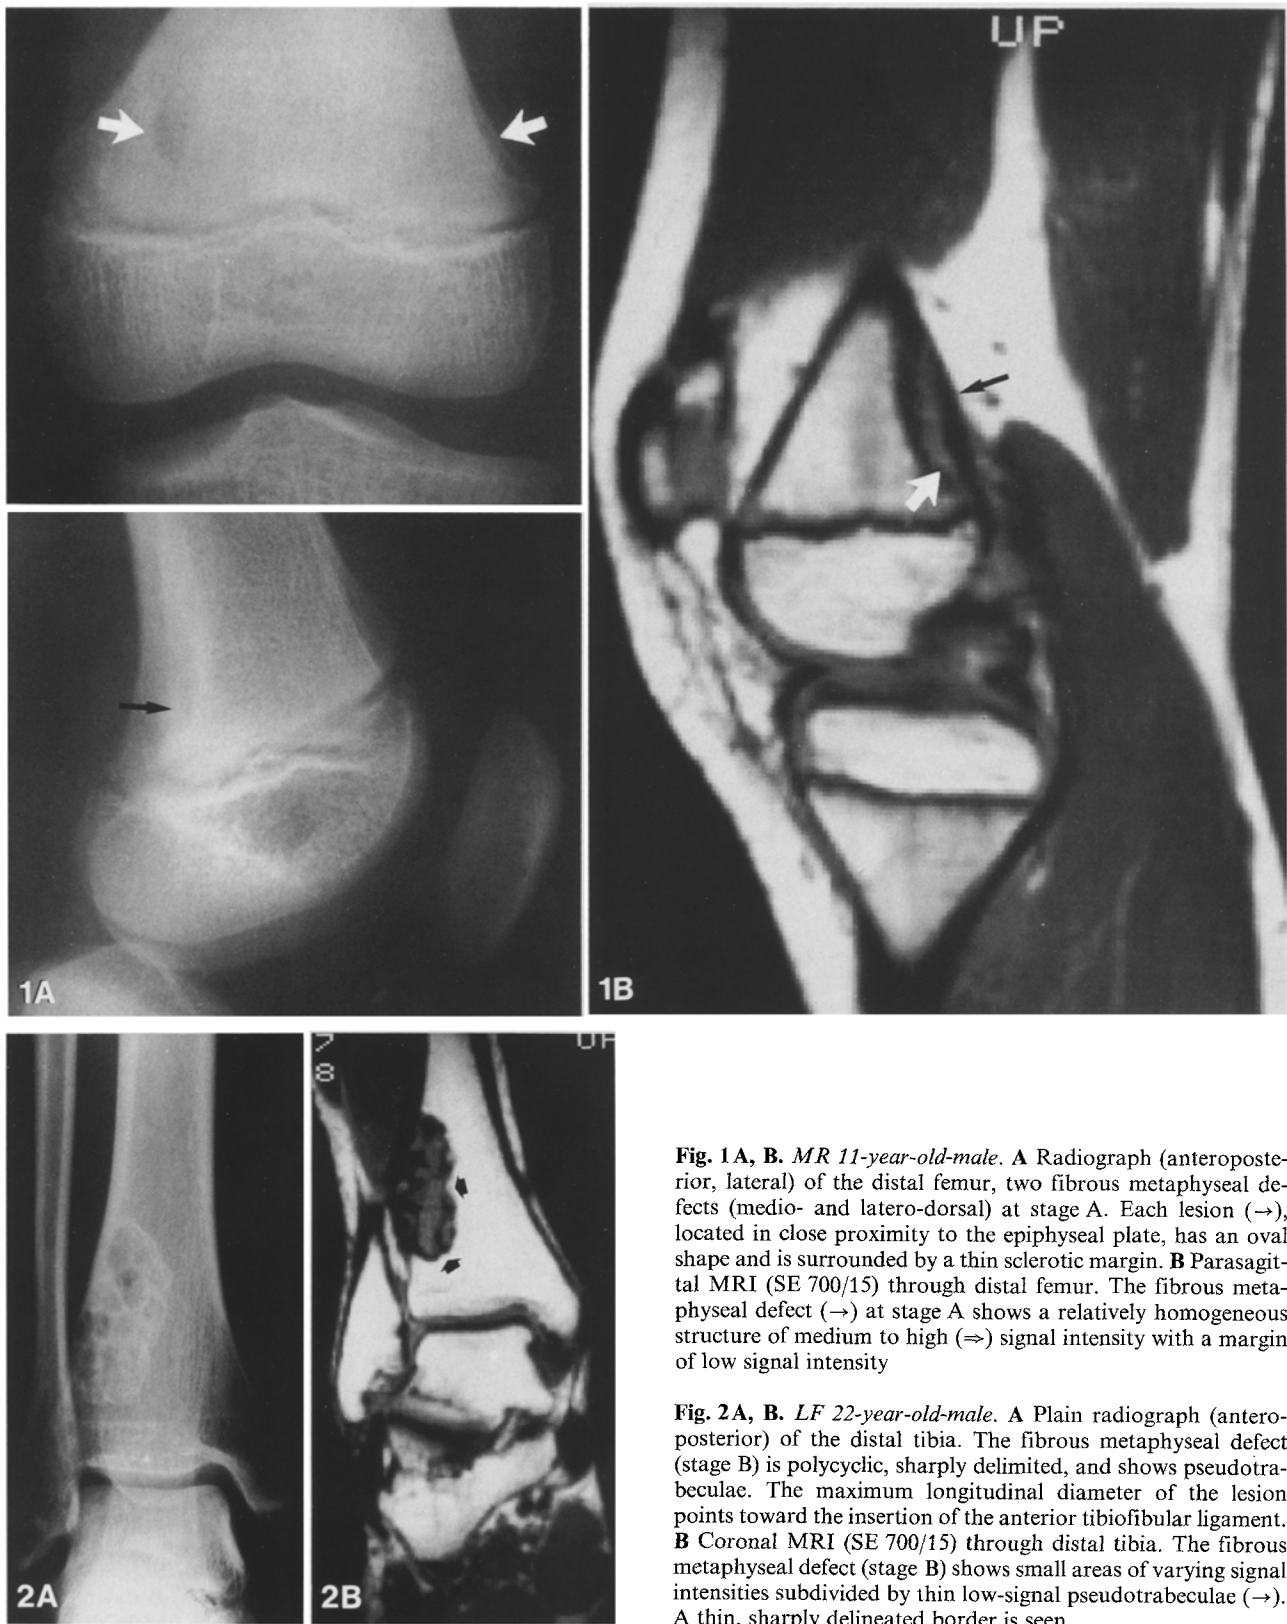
MR 11-year-old-male. A Radiograph (anteroposterior, lateral) of the distal femur, two fibrous metaphyseal defects (medio- and latero-dorsal) at stage A. Each lesion (→), located in close proximity to the epiphyseal plate, has an oval shape and is surrounded by a thin sclerotic margin. B Parasagittal MRI (SE 700/15) through distal femur. The fibrous metaphyseal defect (→) at stage A shows a relatively homogeneous structure of medium to high (⇒) signal intensity with a margin of low signal intensity
